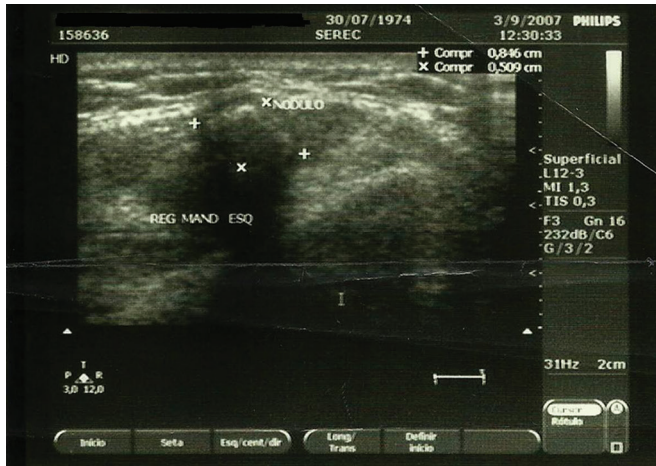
Ultrasonography exam demonstrating an image that is compatible with a solid nodule.
